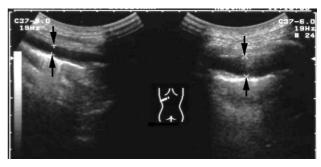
Sonograms in a patient with right upper lobe lung cancer. Images show a thin (5 mm, arrows) fluid collection during inspiration (left image) that was more conspicious (10 mm, arrows) during expiration (right image).
